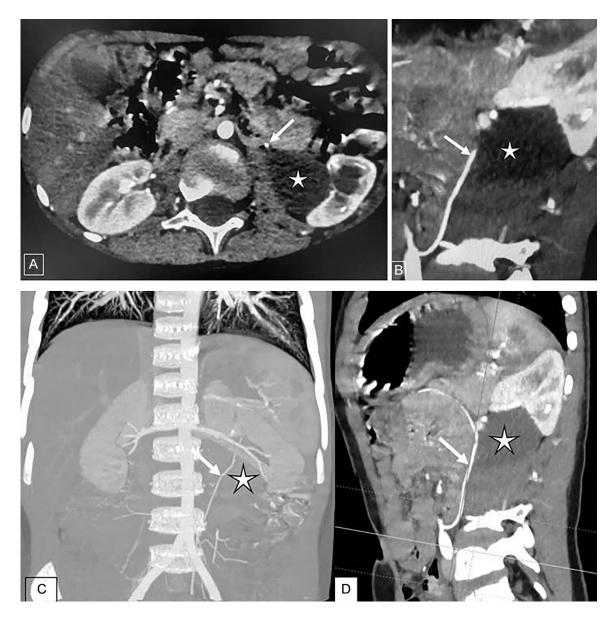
Contrast enhanced abdominal CT scan in arterial phase; (A) axial, (B) coronal oblique thin slices, (C) maximum intensity projection coronal reconstructions thick slices; and (D) coronal oblique (D) showing left renal pelvic dilation (white star) associated with crossing aberrant inferior mesenteric artery (white arrow) at the level of left ueretropelvic junction (UPJ).
